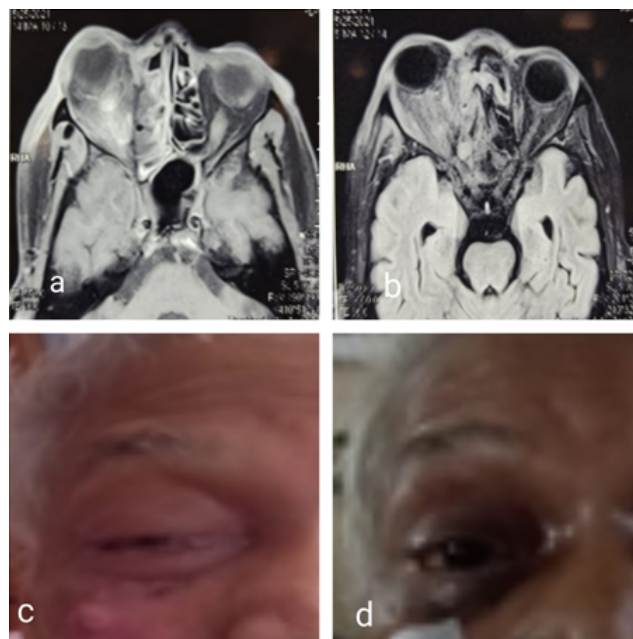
a: MRI of the patient involvement of ant and post ethmoid sinus with right intraconal and extraconal involvement of the orbit; b: T2 weighted MRI image showing involvement of right ethmoid and sphenoid sinus along with intra and extraconal involvement of right orbit; c: Pre FESS photo of patient showing complete ptosis and abscess on right cheek; d: Post FESS photo shows decreased swelling, and moderate ptosis.
